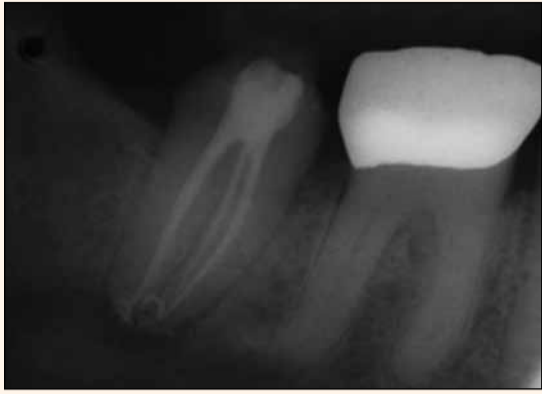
Radiograph of endodontic treatment on #47.
